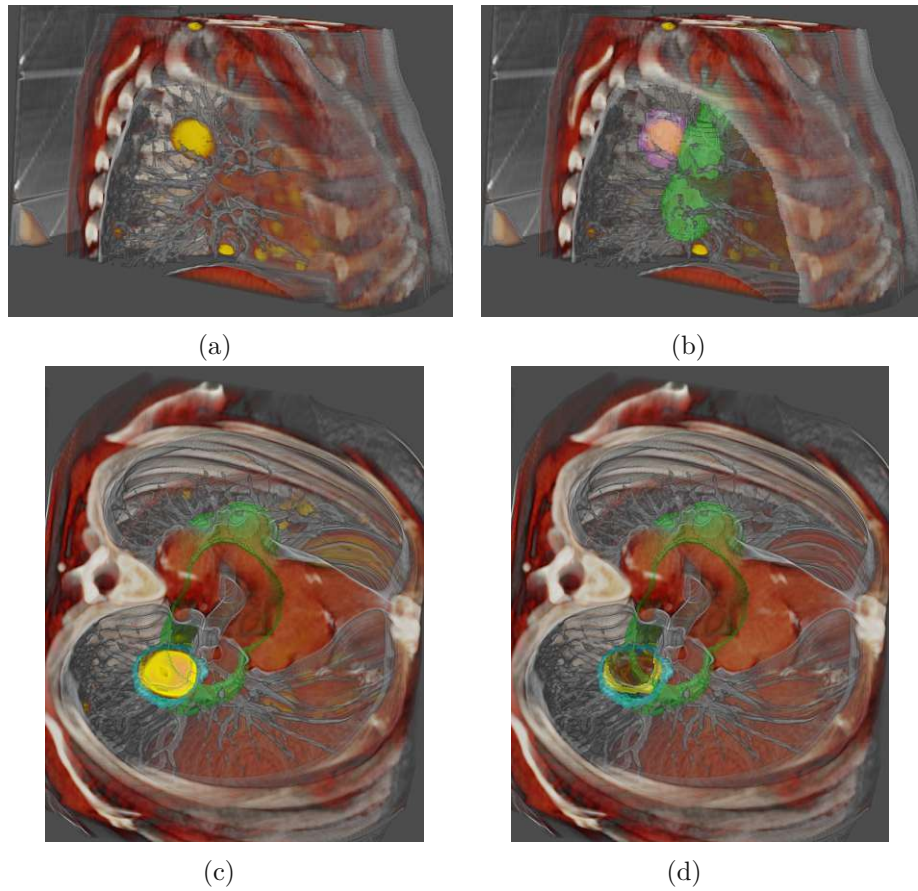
Fusion of a different number of modalities: (a) Fusion of PET, CT. (b), (c) PET, CT, and segmentation. (d) CT and segmentation. Different parameters for clipping were applied to hide parts of the thorax.
